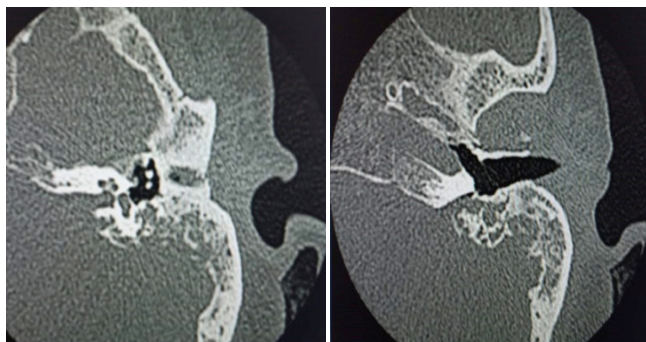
Axial CT images demonstrate an osteolytic lesion along the medial petrosal bone, in the location of the left endolymphatic sac. The bone window shows extensive destruction of the petrous bone, extending to the internal auditory canal and mastoid air cells.
